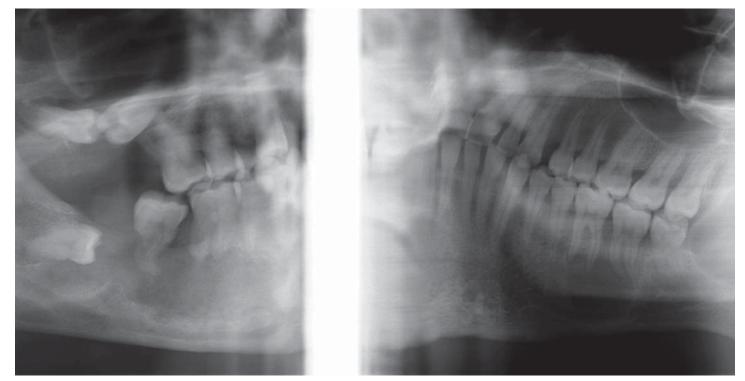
Initial radiograph with multiple radiolucencies and displacement of teeth and inferior alveolar nerve.
